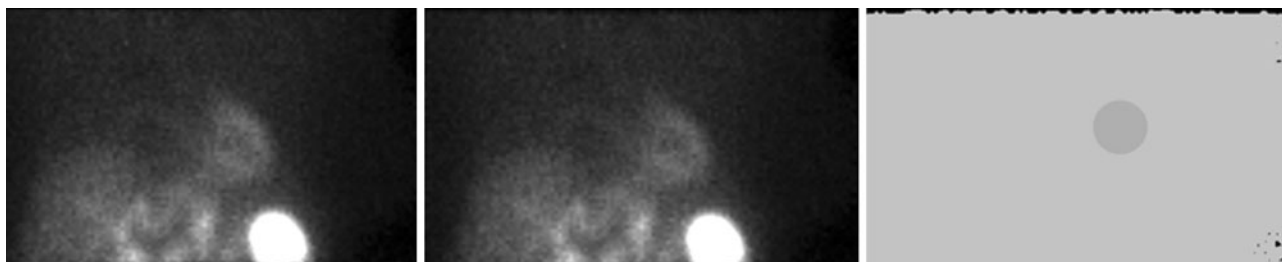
Displayed is an anterior projection from a SPECT study (*left*), the same study with a 10% loss of count in a circular ROI in the anterior wall of the heart (*center*), and the sensitivity mask identifying the circular ROI. A 10% loss of sensitivity is barely visible in the anterior wall of the center of the image of the patient, and yet it could have a significant impact on the interpretation of the study.
